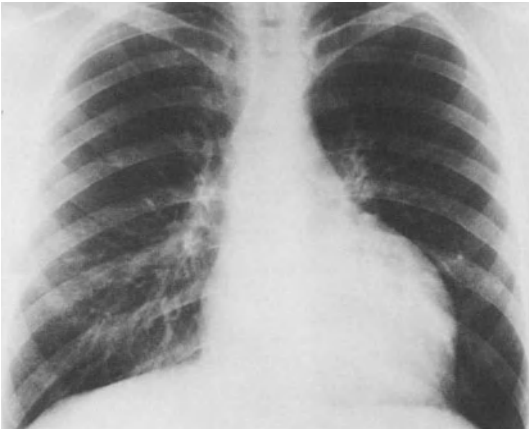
Chest X-ray in a case of hypertrophic obstructive cardiomyopathy demonstrating concentric left ventricular hypertrophy manifested by a rounding and bulging of the left cardiac border (left)
